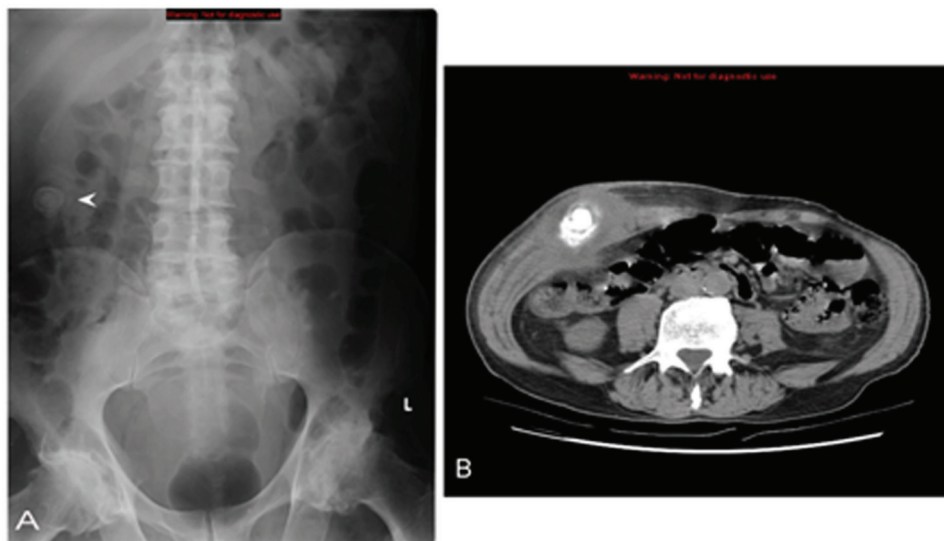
(A) Abdominal x-ray demonstrating calcified gallstone (arrowhead). (B) CT demonstrating a large gallstone within a grossly inflamed gallbladder extruding through anterior abdominal wall, marked overlying tissue inflammation and fistulous tract.
